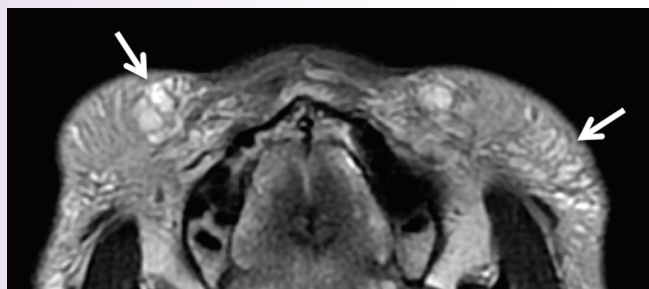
Collagen filler injections for malar augmentation seen on an axial T2-weighted MR image as increased subcutaneous infiltration and areas of lobular T2 hyperintensity (arrows).
